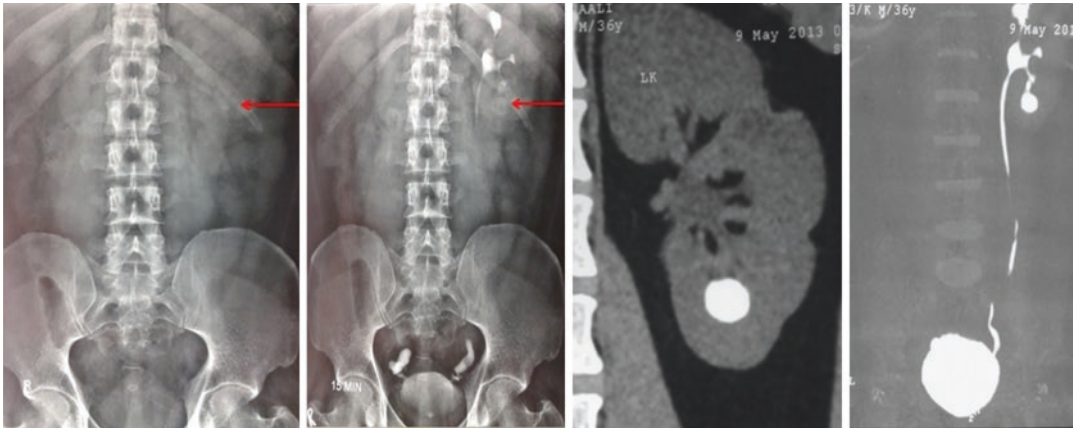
Imaging of a patient with left renal lower pole calyceal diverticular stone with X-ray KUB and plain CT
